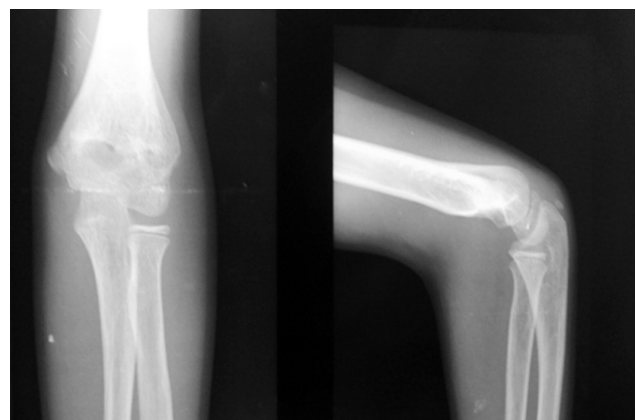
Follow up X-rays of elbow – AP and lateral views, at 6 months
